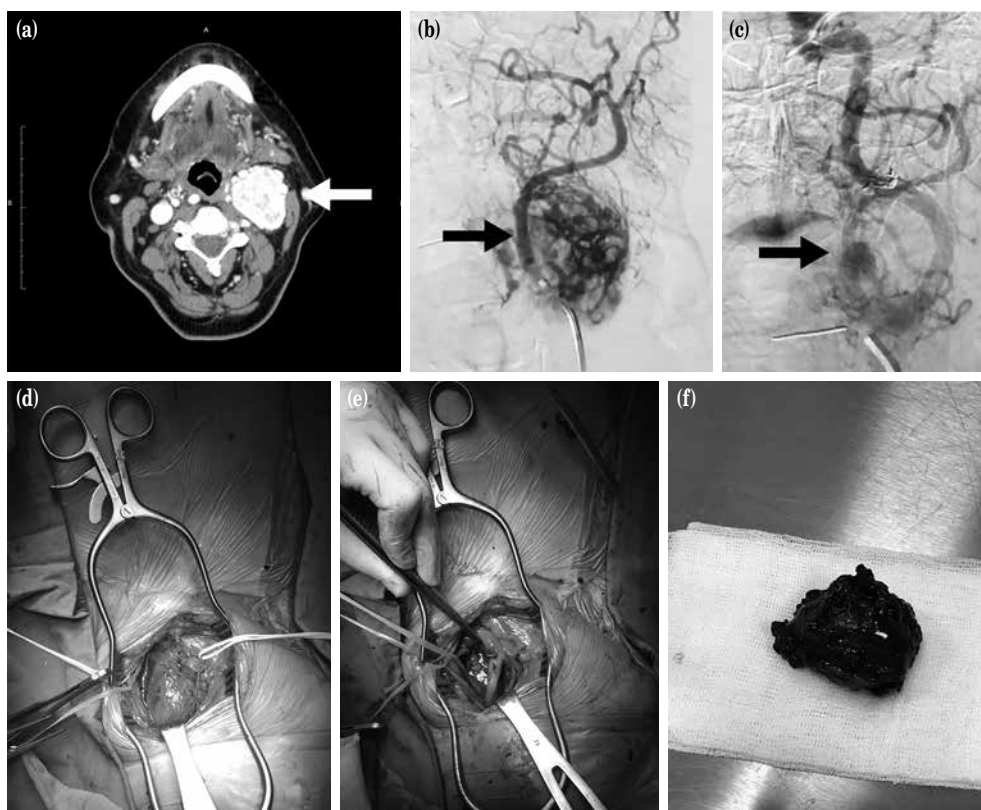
(a) A vascularized mass with a diameter of 4×4 cm on computed tomography angiography surrounding left common, internal, and external carotid arteries. (b) Preoperative angiographic view prior to surgical embolization. (c) Preoperative angiographic view following surgical embolization. (d) Intraoperative view of carotid body tumor prior to resection. (e) Intraoperative view of carotid arteries following resection. (f) Intraoperative resected carotid body tumor.
